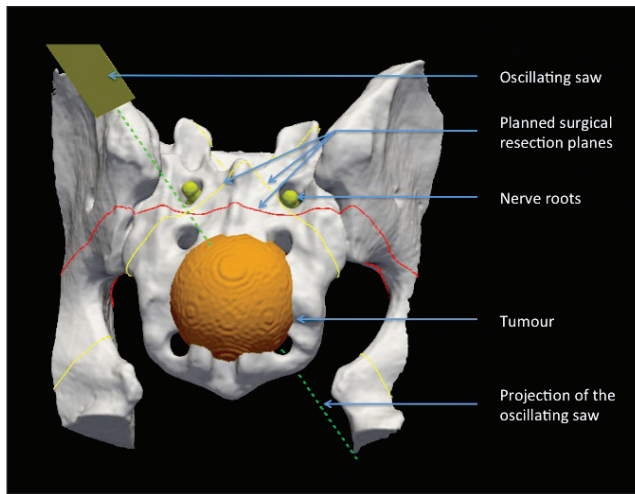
The CT of a sacral sawbone model with pre-operative planning highlighted, including the delineation of the tumour, sacral nerve roots, and surgical resection planes planned.
